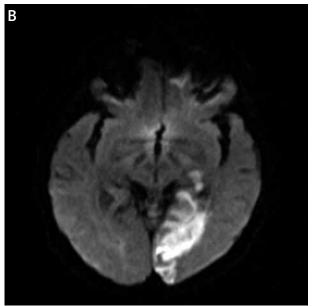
Diffusion weighted MRI of the brain. Cerebral images, including the cerebellum and brainstem, before (A) and after (B) the transcatheter aortic valve implantation procedure. This patient had one, large new cerebral infarct
